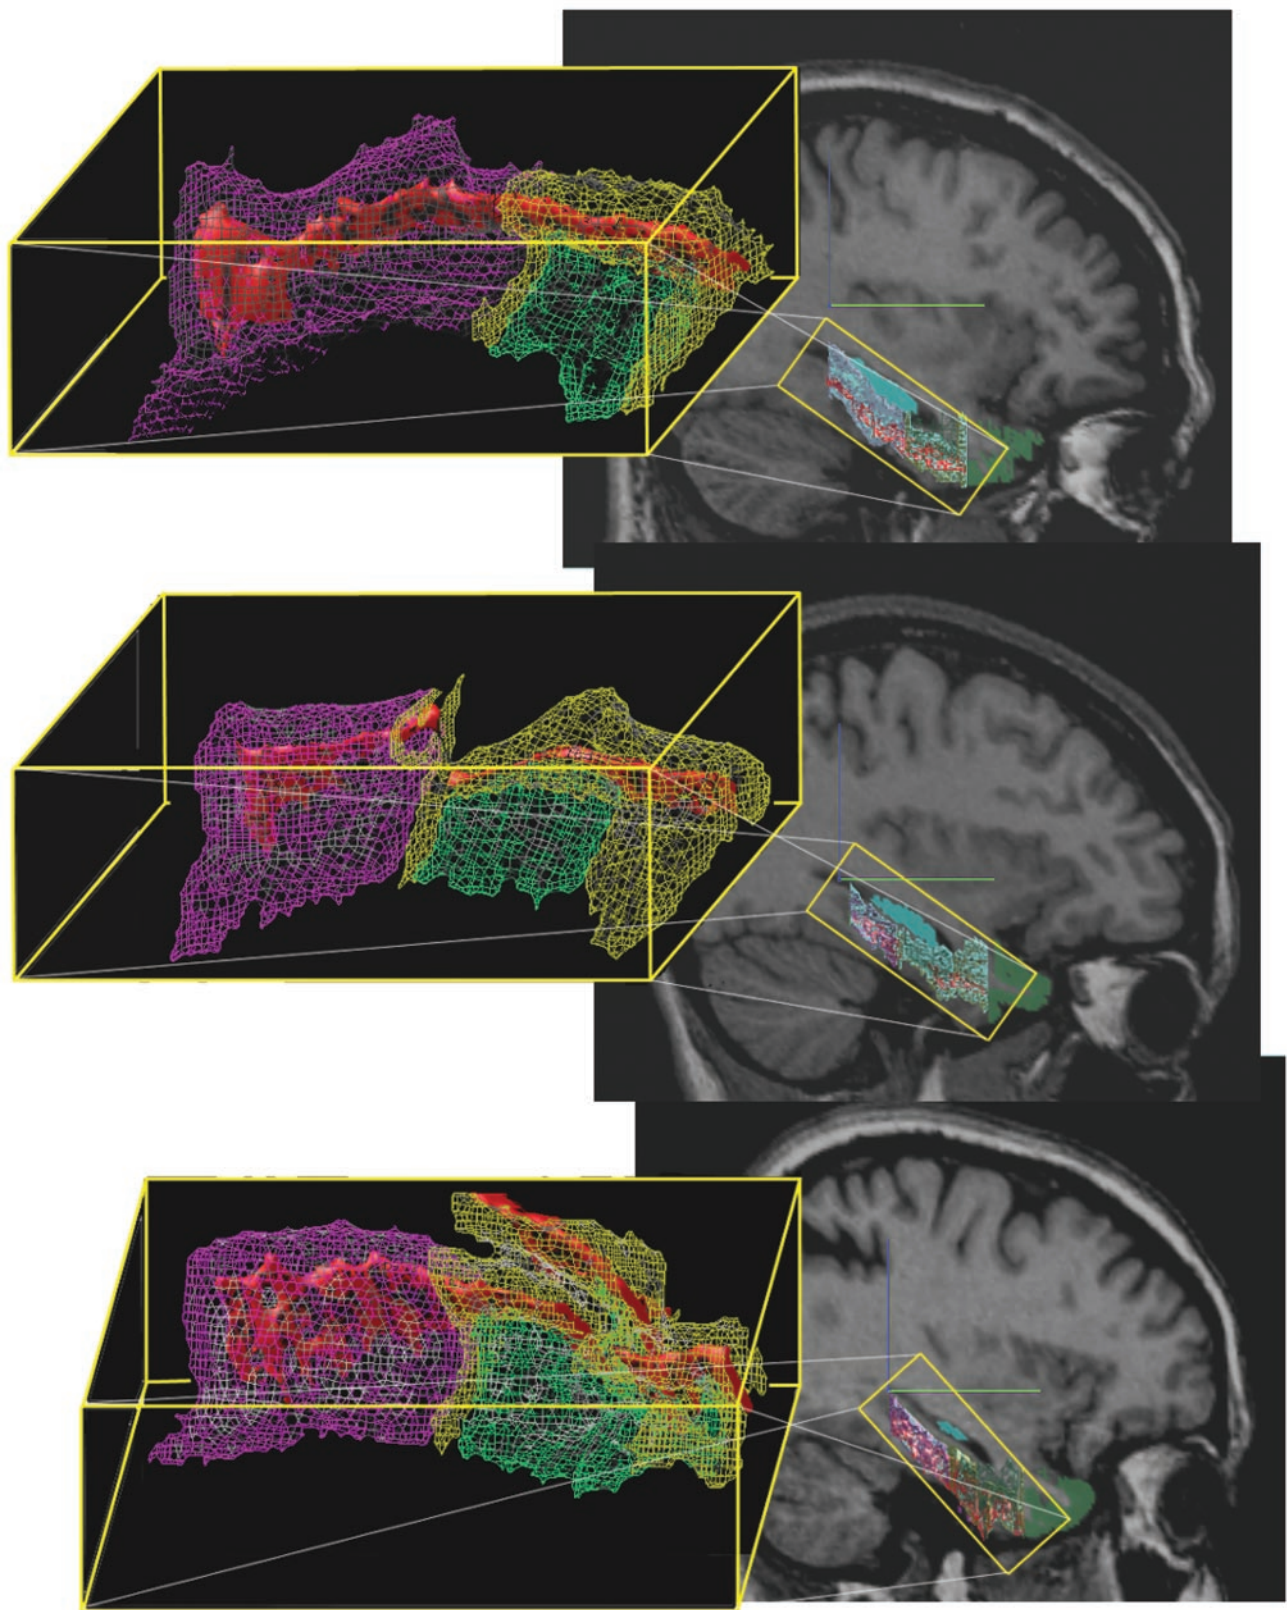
Effect of anatomical variation of the MTL on the volumes of EC, PRC and PHC. Three anatomical variations of MTL lobe anatomy are shown, with an uninterrupted, non-side-branched CS shown in the upper row, an interrupted CS shown in the middle row and a side-branched CS shown in the lower row. For better visualization, corresponding segments of the CS were cut out from the MR image and underwent 3D rendering. The CS is shown in solid red in all examples. The surrounding gray matter structures are rendered as mesh wire around the CS. PRC is displayed in yellow, EC is shown in green and PHC is displayed in pink. An interruption of the CS will have an effect of reduction on the volumes of PRC and EC, as can be seen when comparing the upper and the middle row. A side branch of the CS will cause the volume of the PRC to be enlarged, as can be seen when comparing the upper and the lower rows. By computing a cortex-to-CS ratio (possible after segmenting the CS itself), the volumes of the gray matter structures surrounding the CS can be corrected for anatomical variations of the CS.
